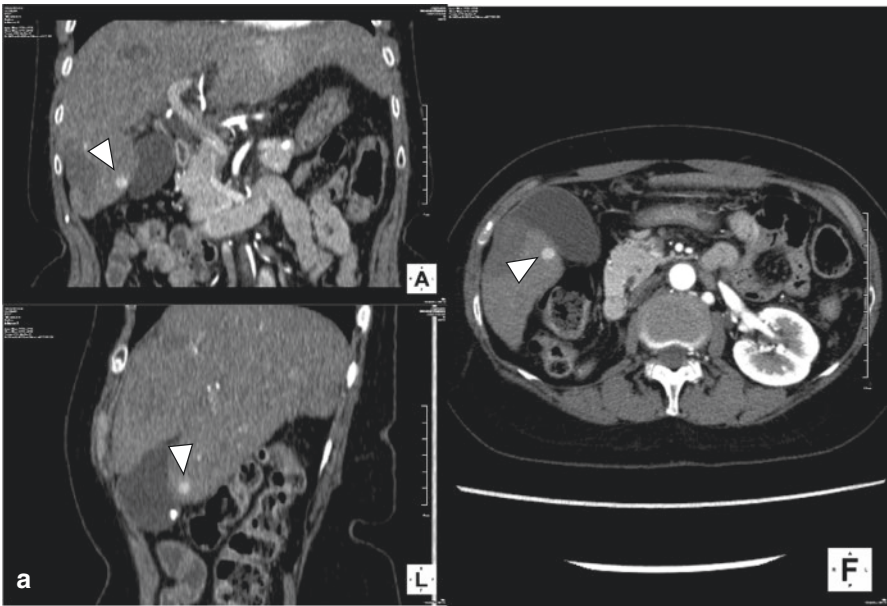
Representative case with recurrent HCC treated with artificial ascites. (a) Enhanced CT before ablation. A small nodule in segment 6 adjacent to the gallbladder and the ascending colon (arrow head). (b) An ultrasonographic image during ablation. An electrode was inserted to the tumor after the infusion of 5% glucose solution. (c) Enhanced CT after ablation. The target was completely ablated without any damage to adjacent organs (arrow head)
